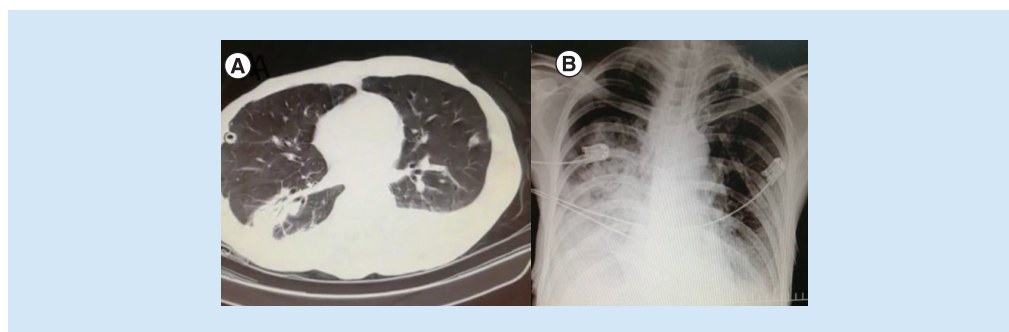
(A) Chest CT scan showing right inferior lobe pneumonia. (B) CXR showing right inferior lobe infiltrations. CT: Computed tomography; CXR: Chest X-ray.
